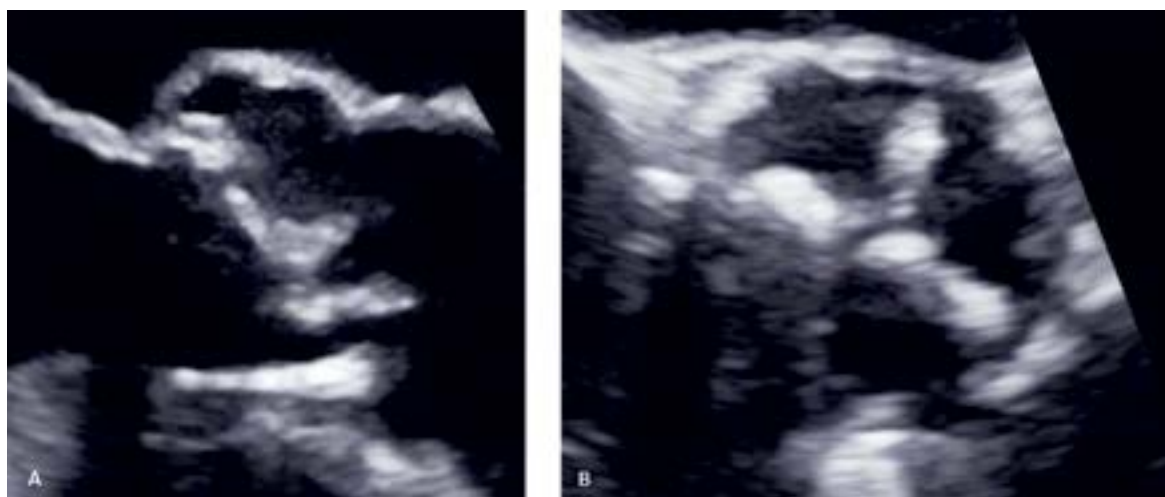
Structural valve degeneration of a Sorin Mitroflow Aortic Bioprosthesis of a 77-year-old female patient (no. 6) 4 years after surgical aortic valve replacement. (A) Transesophageal long axis view. (B) Transesophageal short axis view. Videos A and B can be seen in the multimedia collection of Cardiovascular Medicine: <https://cardiovascmed.ch/online-only-content>.
